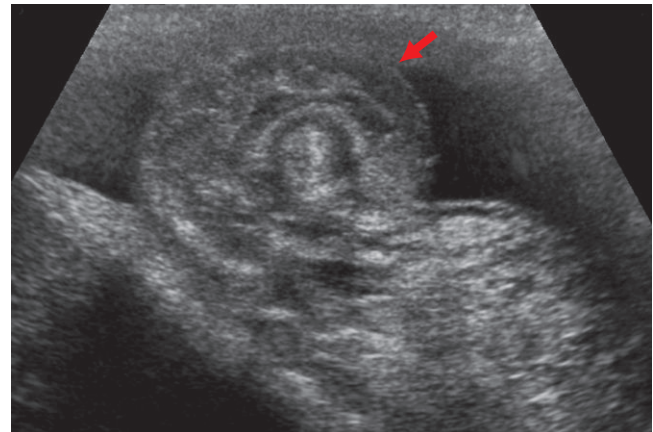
The gray scale sonographic image shows a twisted cord (torsion knot) (arrow).
